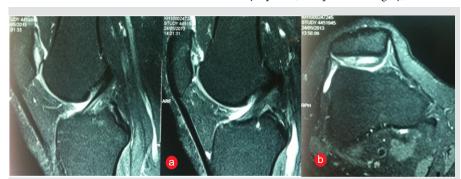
a) T2 weighted sagittal MRI images of 39 years old female suffering from right knee pain for 1 year, of insidious origin. MRI shows patellar chondral defect with a fluid interface between the cartilage and the patellar subchondral bone. There are areas of cartilage separation seen in another sagittal image as well as axial image (b).
